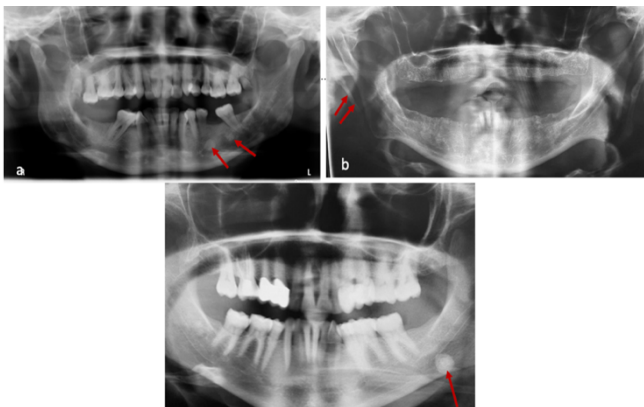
a-) Panoramic radiograph showing two idiopathic osteosclerosis in the left mandibular premolar-molar region.
